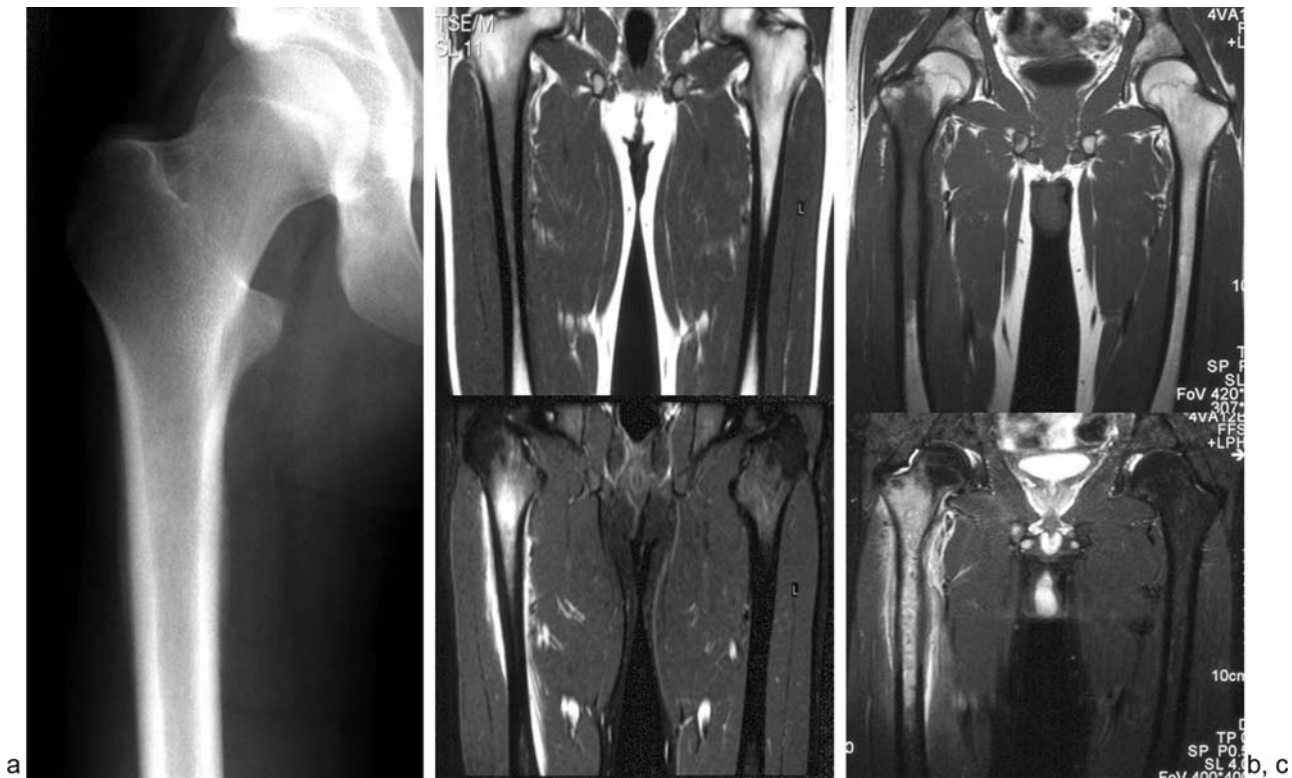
(a) Anteroposterior radiograph of the hip, (b) coronal T1-weighted and short tau inversion recovery images, and (c) the same at follow-up 2 months later. The lamellar periosteal reaction on the radiograph and predominantly edema pattern on the initial magnetic resonance imaging (MRI) was interpreted as suggestive of a stress fracture of the proximal femur. The patient's symptoms did not resolve on rest, and the lesion had shown significant progression with extraosseous soft tissue on the second MRI. Biopsy confirmed Ewing's sarcoma.
